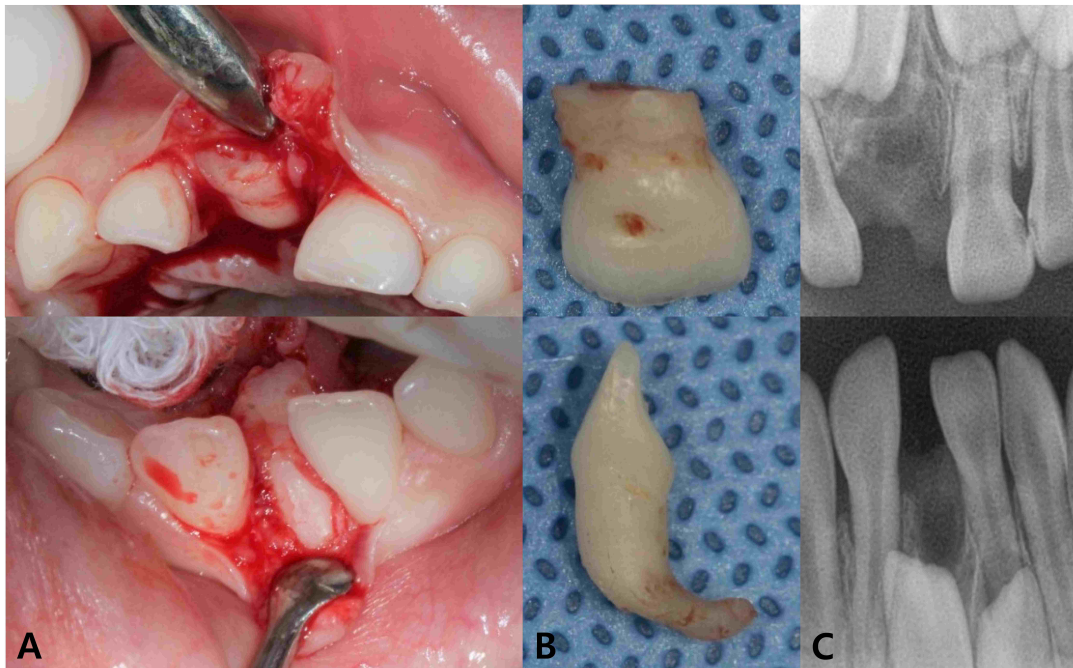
Extraction of impacted teeth #51 and #81 under general anesthesia. (A) Teeth #51 and #81 were displaced to the palatal and lingual sides, respectively. (B) Crown and root shapes of teeth #51 and #81. (C) Periapical radiograph after extraction.
